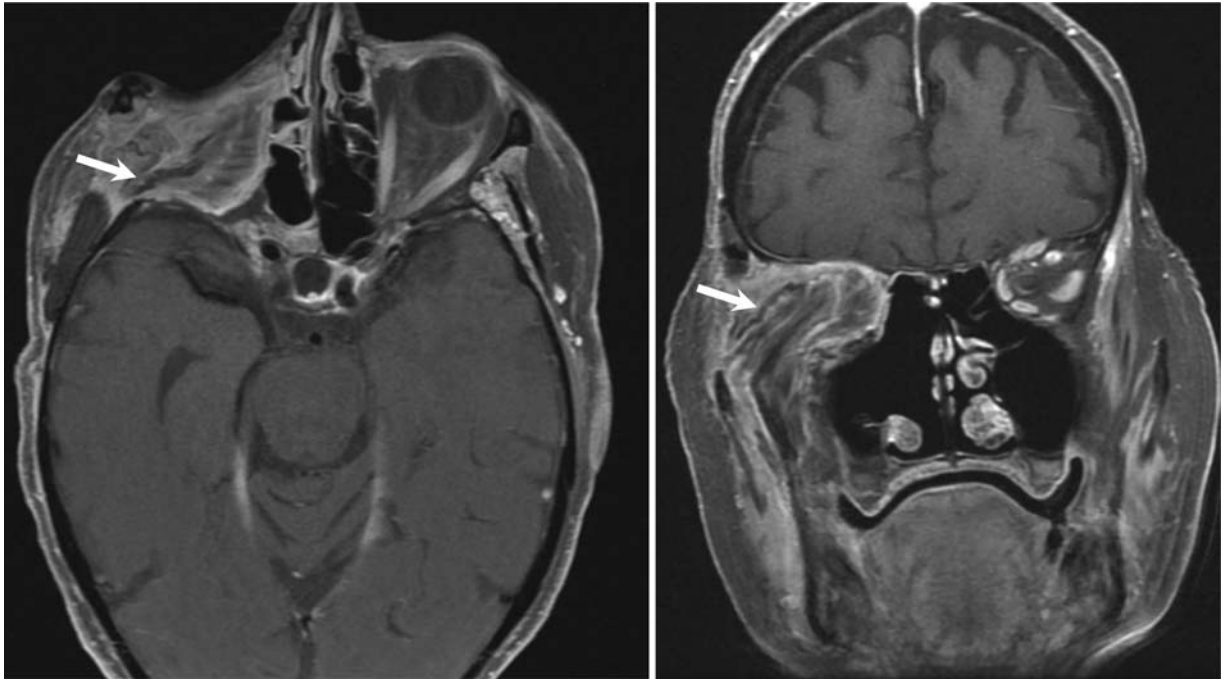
Postoperative axial (A) and coronal (B) post contrast T1-weighted MRI images showing complete removal of the tumor with a temporalis muscle rotational flap (arrow) covering the dura and orbital apex and filling the orbital defect. A positive margin at the superior orbital fissure was treated with radiosurgery. MRI, magnetic resonance imaging.
